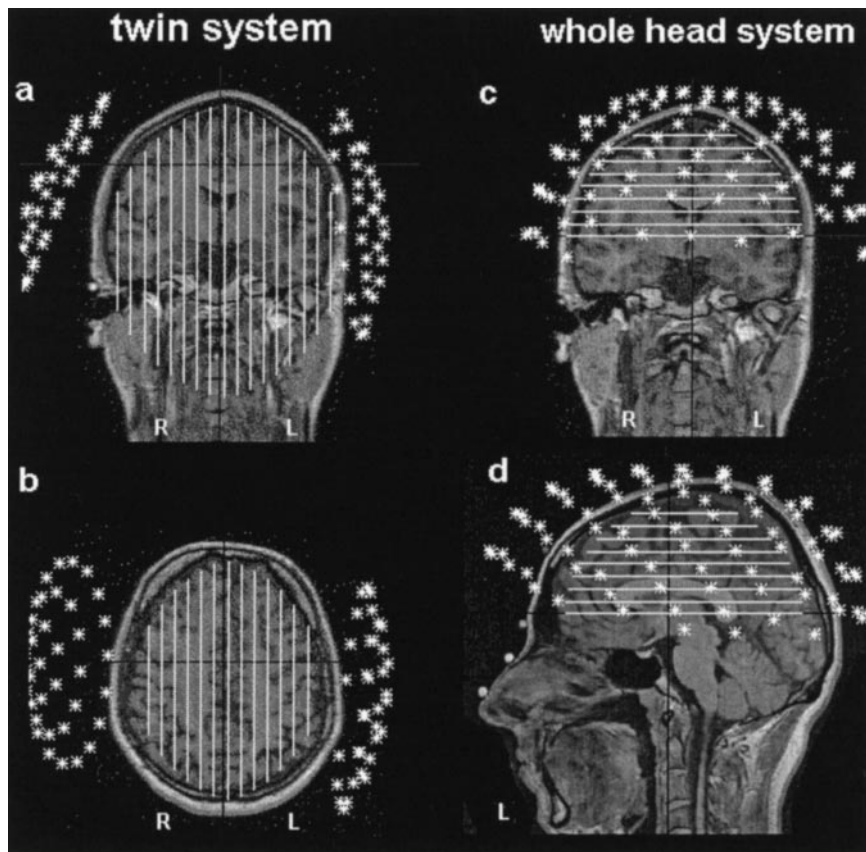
Channel selection and source space definition. (a and b) The channel layout for Experiment 1 performed with the BTi MAGNES II system and the respective left and right source spaces, used for the MFT reconstructions. Nine sagittal slices are shown for each source space, each appearing as a line in the coronal and axial MRI slices displayed (the deepest slice is common to the left and right source spaces). (c and d) The 90 channels and the top source space used in addition to the lateral source space estimates for the MFT analysis of the helmet MEG data. The coronal and sagittal views are shown, with the nine levels of the top source space cutting the displays at axial planes projected as lines on the display.
